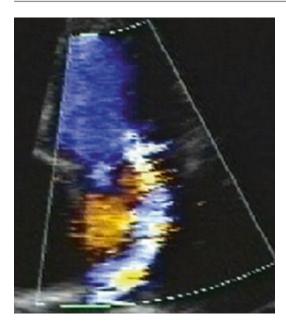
Colour Doppler imaging showing the extent of mitral regurgitation. Calculated regurgitant volume 35 mls (moderate)
